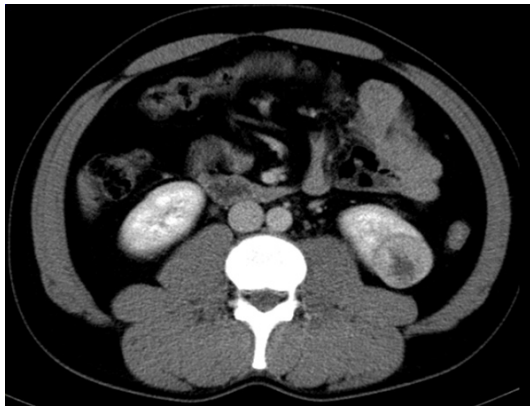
Abdominal CT scan revealed a well-defined, round mass in the lower pole of left kidney.
